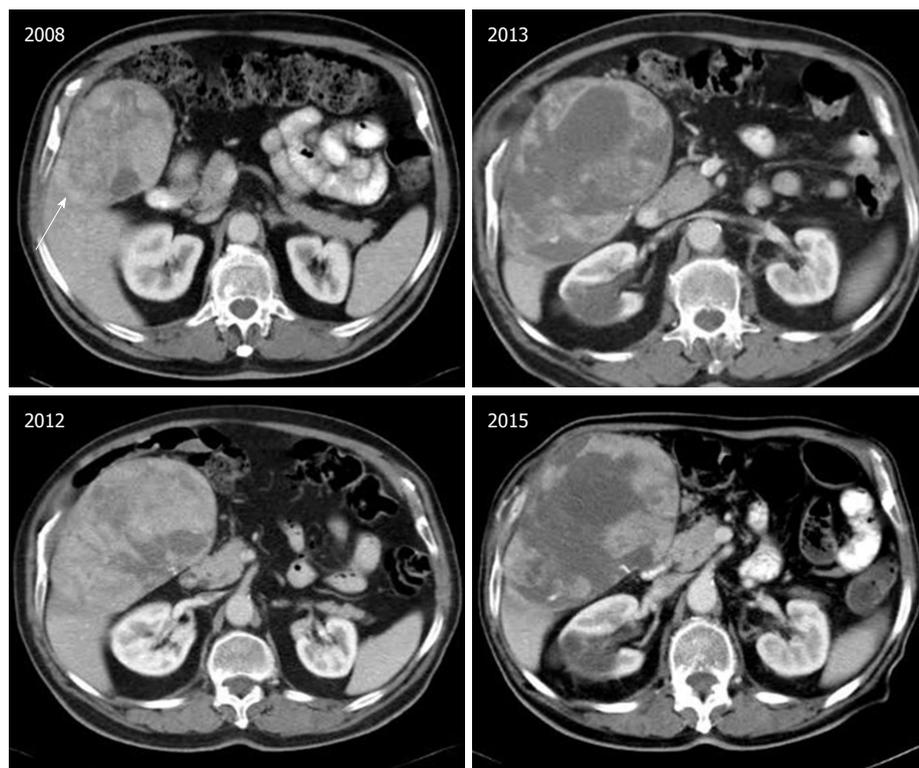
Serial computed tomography scans of a hepatocellular carcinoma patient with multiple co-morbidities precluding radical treatment, surviving 7 years with sequential approach in systemic treatment (Octreotide long acting release, followed by sorafenib). Despite an increase in tumor size, it is evident the central necrosis related to Sorafenib treatment (which was commenced when it became available).
